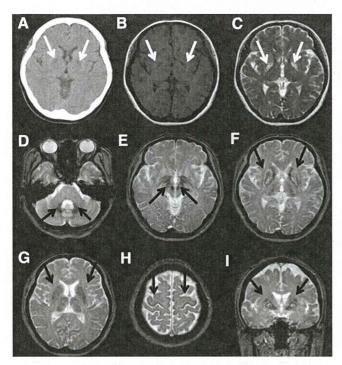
CT and MRI scans of the proband at the age of 44. A. Axial head CT showing symmetrical hypodense lesions in the basal ganglia, bilaterally. B. T1-weighted axial MRI image showing symmetrical hypointense areas in the basal ganglia, revealing the degenerative and partially cystic nature of the lesions. C. T2-weighted axial MRI image showing symmetrical hyperintense areas encircled by hypointense areas in the bilateral posterior globus pallidus and putamen. D–H. T2*-weighted axial MRI images showing hypointense areas in the dentate nucleus (D), red nucleus (E), globus pallidus, putamen, caudate, thalamus (F, G), and cerebral cortex (H), suggesting increased deposition of ferritin in multiple nuclei. I. T2*-weighted coronal MRI image showing a hypointense rim and a hyperintense center reminiscent of the "eye of the tiger" sign in the basal ganglia.
